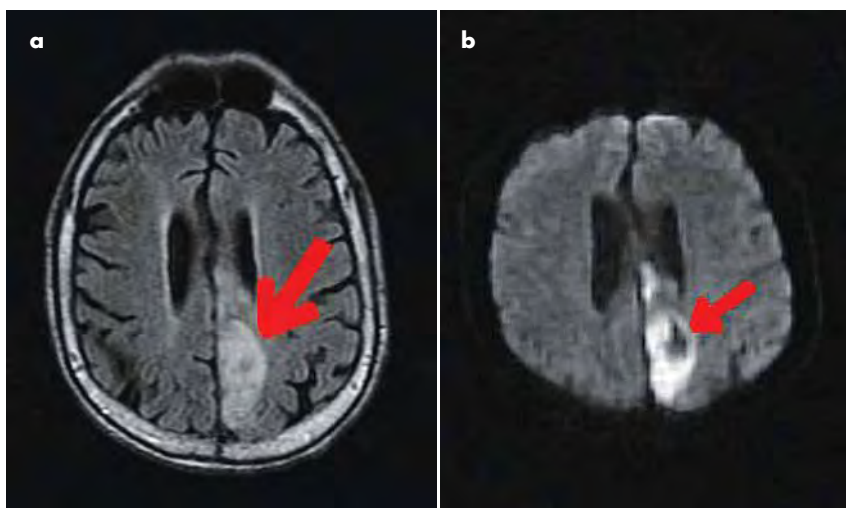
MRI of the brain T2 image (a) and diffuse-weighted image (b) showing acute infarct.
